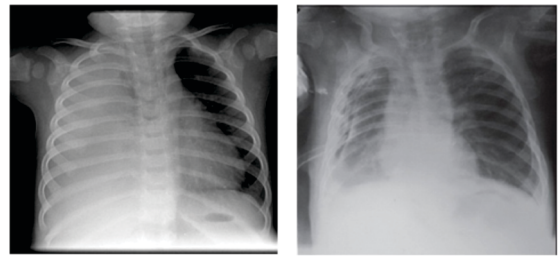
initial xray chest before ICD Figure 2: post ICD
